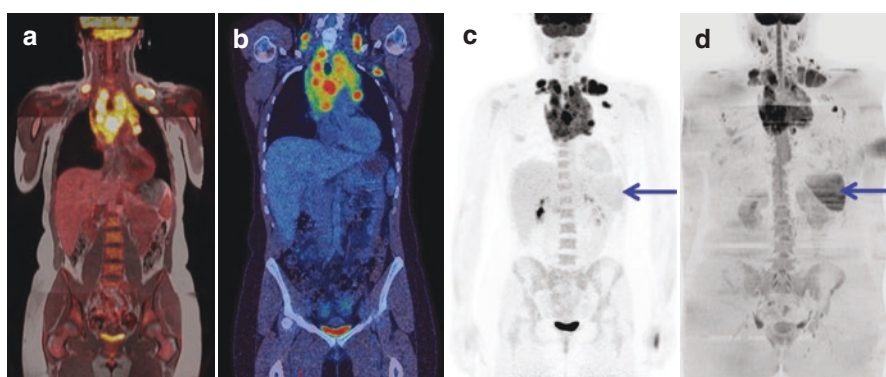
Demonstrates a patient scanned with PET/MRI (a) and PET/CT (b) after a single administration of FDG on the same day. Note that the spleen has normal activity on FDG PET/MRI (c) but restricted diffusion on DWI (d) (courtesy of Dr. Andrew Mallia, PET Imaging Centre at St Thomas', King's College London)
